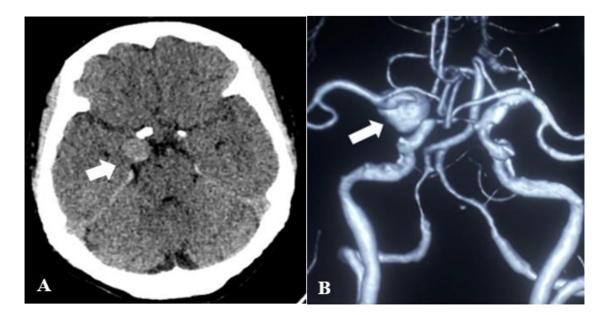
The aneurysm on 64-slice computer tomography angiography (CTA). (A) An aneurysm on 64 slice CTA without contrast; (B) an aneurysm in the right internal carotid artery on CTA.
